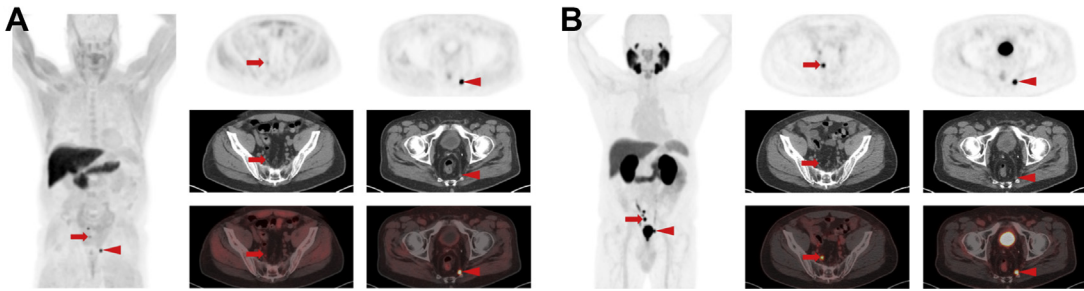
A 74-year-old man with biochemical recurrence of PCa after radical prostatectomy. (A) ^{18}F -fluciclovine PET whole-body MIP image showing multiple radiotracer-avid pelvic lymph nodes as well as axial PET (top row), CT (middle row), and PET/CT (bottom row) images. (B) PSMA-targeted ^{18}F -DCFPyL PET whole-body MIP image showing multiple radiotracer-avid pelvic lymph nodes as well as axial PET (top row), CT (middle row), and PET/CT (bottom row) images. Although some lesions are more conspicuous with the PSMA agent (red arrows), it also has high urinary excretion that obscures lesions in some images, such as on the MIP (red arrowheads). This patient was imaged on the CONDOR clinical trial protocol (NCT03739684).
